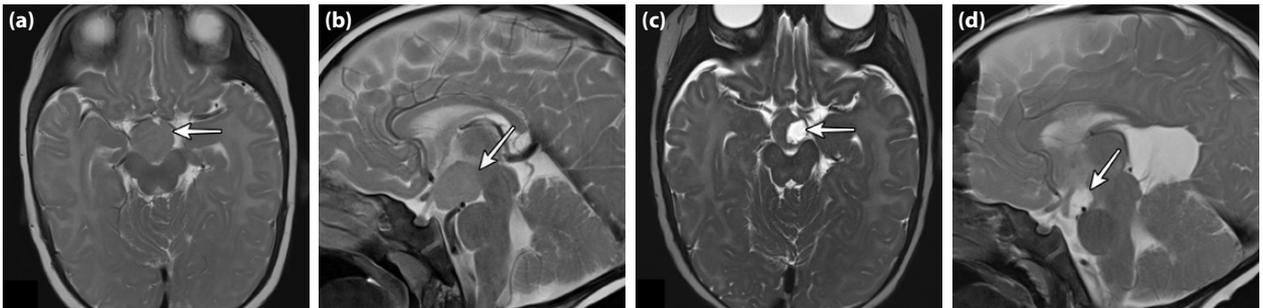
(a) Axial section T2 weighted MRI of a patient with type 4 HH (arrow). (b) Sagittal section T2 weighted MRI of the same patient (arrow). (c) Axial section T2 weighted MRI of the patient after disconnection surgery through the interhemispheric route. Arrow designates disconnection plane. (d) Sagittal section T2 weighted MRI of the same patient after disconnection surgery. Arrow designates the disconnection plane.
